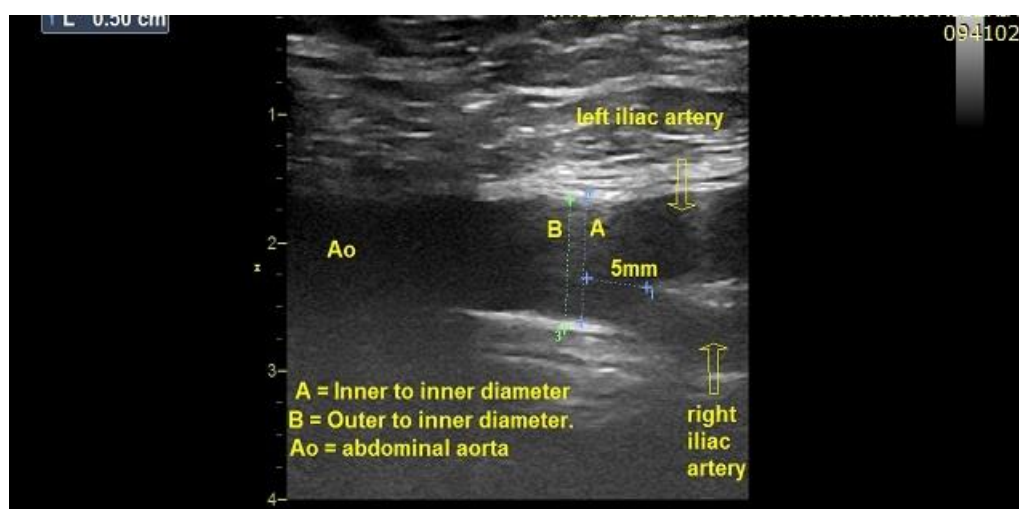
Doppler Sonography of the longitudinal section of the abdominal aorta in healthy subjects showing the measurement of the inner to the inner diameter and outer to inner diameters of the abdominal aorta from which the WT of the abdominal aorta was obtained.
